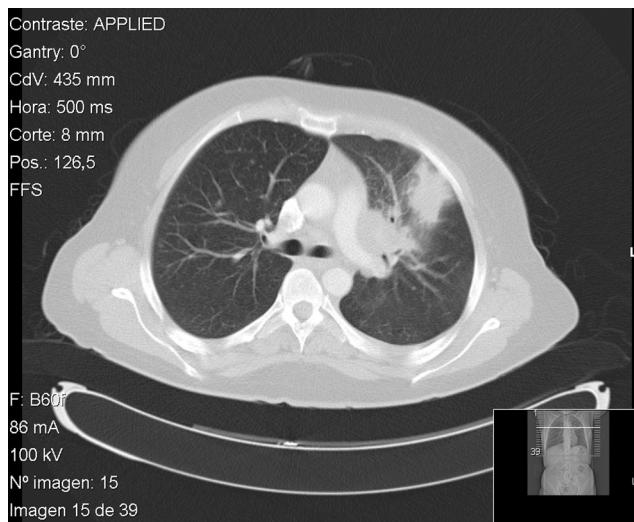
Pulmonary computed tomography showing condensation in left upper lobe, in contact with the anterior costal pleura and accompanied by ipsilateral hilar adenopathy.
